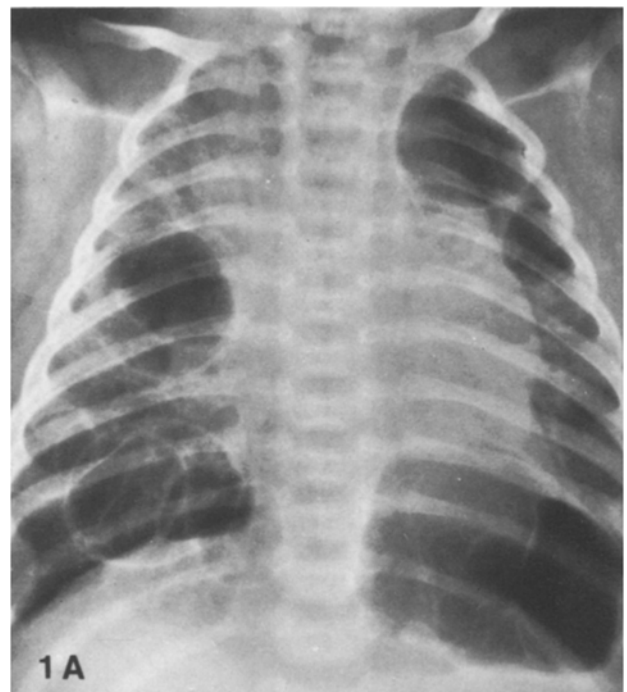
Anteroposterior chest roentgenogram shows bilateral multiple varying sized cystic lesions
